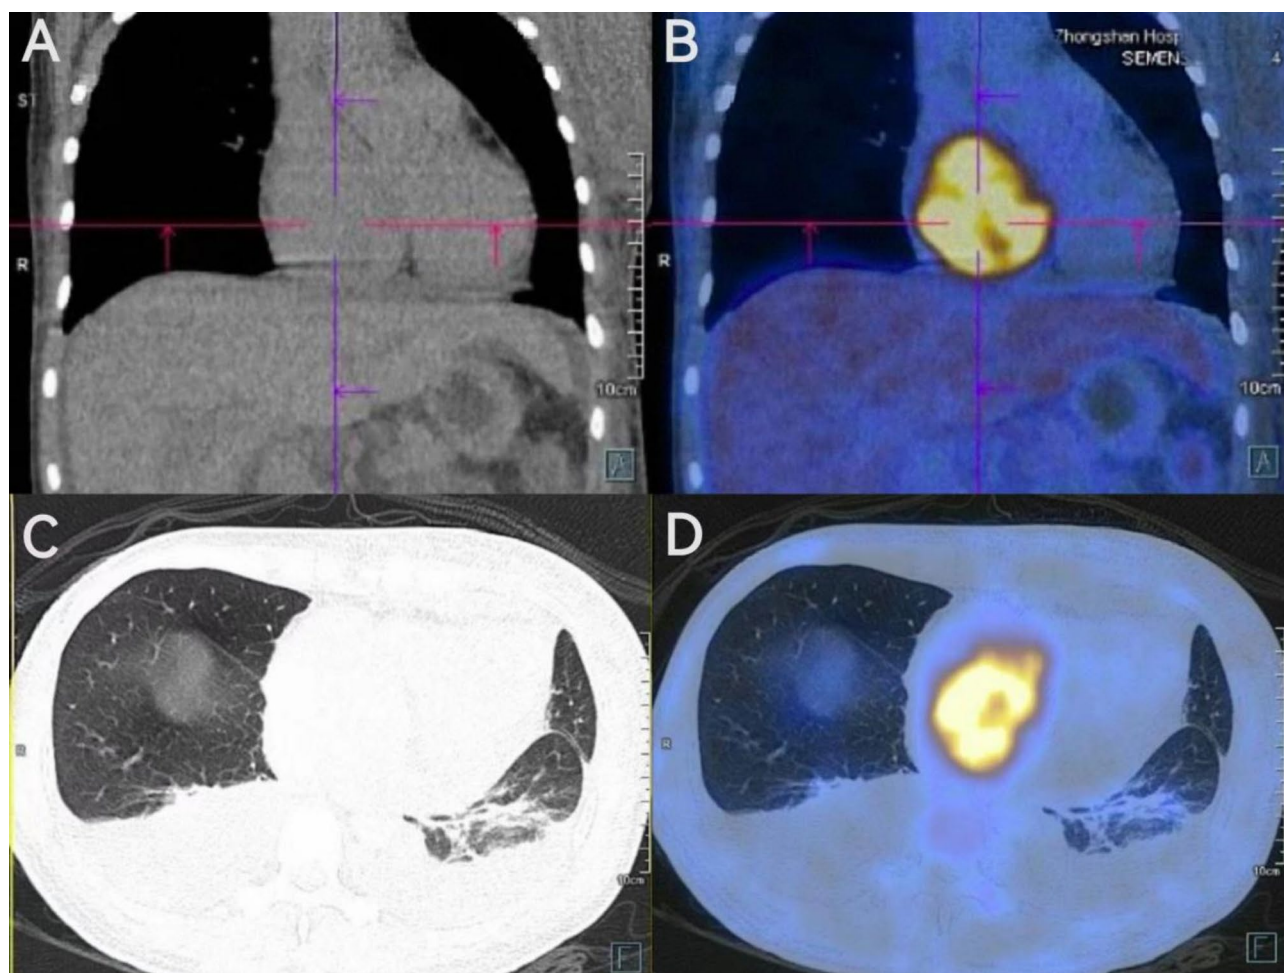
(A–D) PET-CT image demonstrating: (B, D) A mass with abnormally increased glucose metabolism in the left and right atria and atrial septum is not demarcated from the ventricular wall. (C, D) Bilateral pleural effusion
